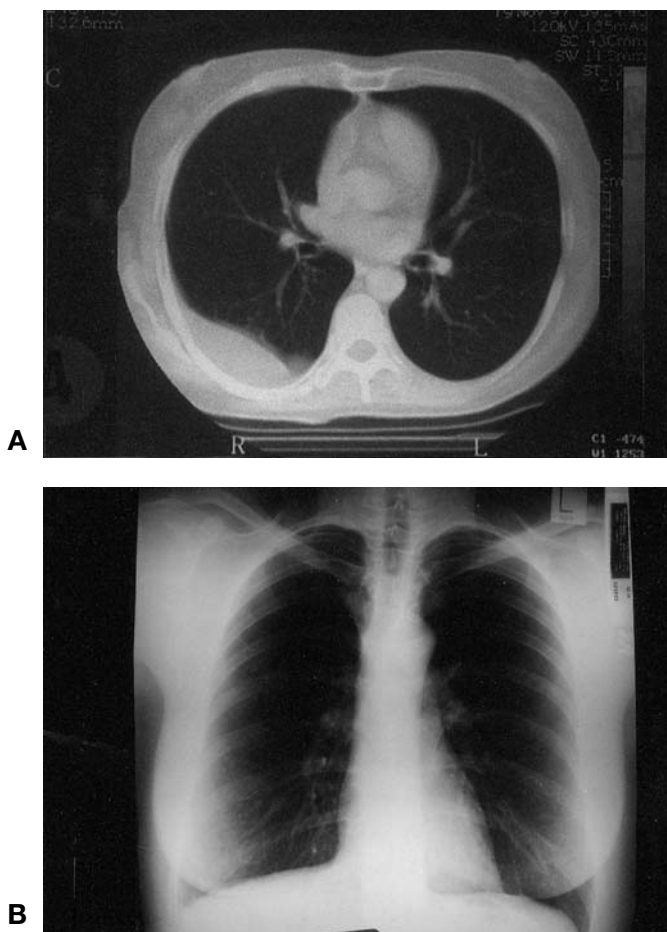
A Chest CT scan at the level of the intermediate bronchus, showing small to moderate amounts of loculated right-sided pleural effusion. B Chest X-ray, same patient, 2 years later: no evidence of pleural effusion. Note the blunted right costophrenic sinus.
